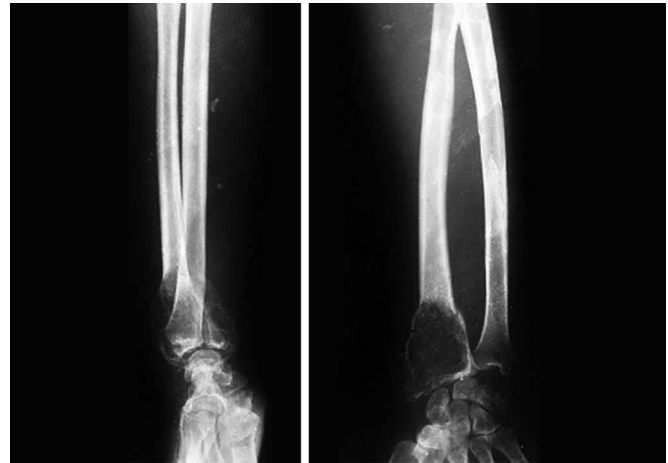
X-ray wrist with forearm AP and lateral views shows pathological fracture in a giant cell tumor (GCT) of distal end of radius.
